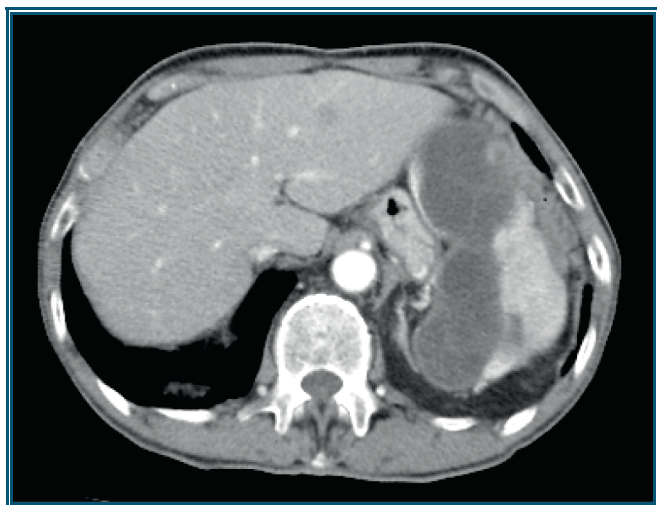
Magnetic resonance imaging of a splenic hydatidosis.
